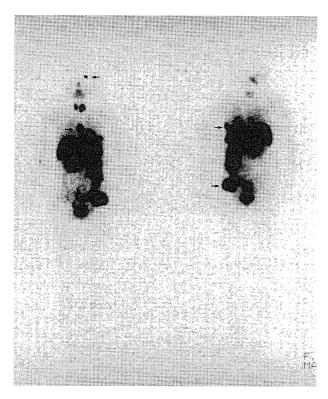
99mTc-MIBI scintigraphy (left: anterior view, right: posterior view) on admission in Case No. 1. Both a primary tumor of the left thyroid lobe and bone metastases were imaged.
